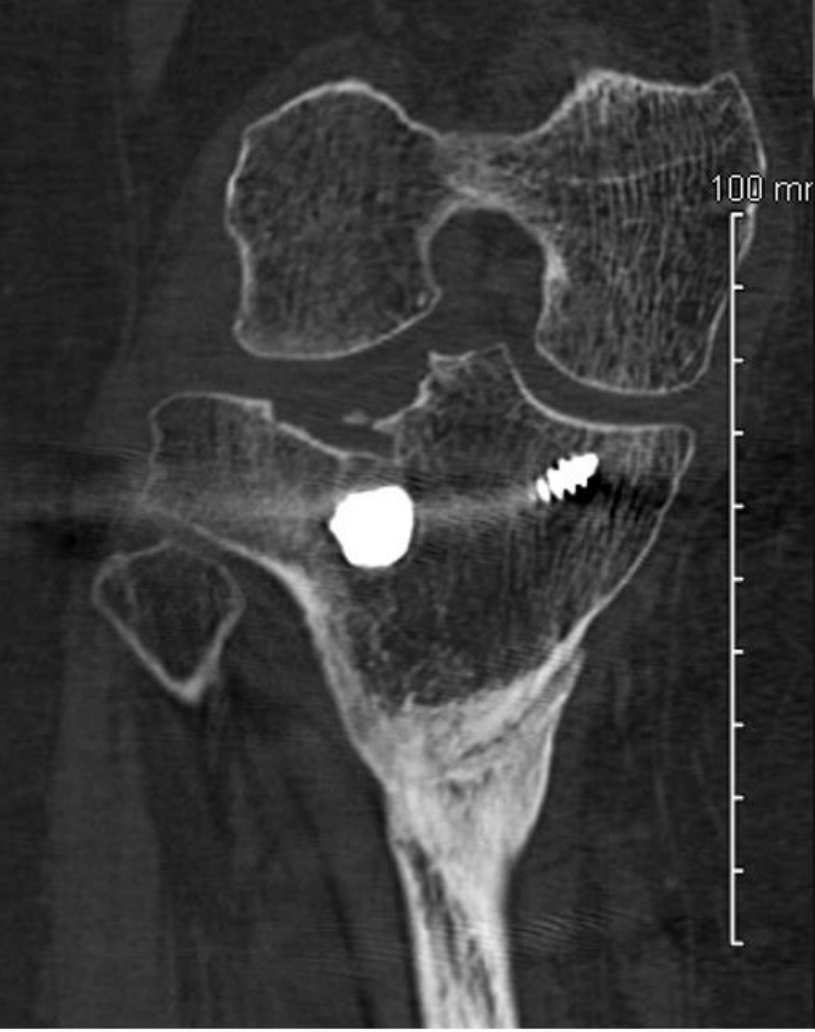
6 years old post operative frontal radiograph
